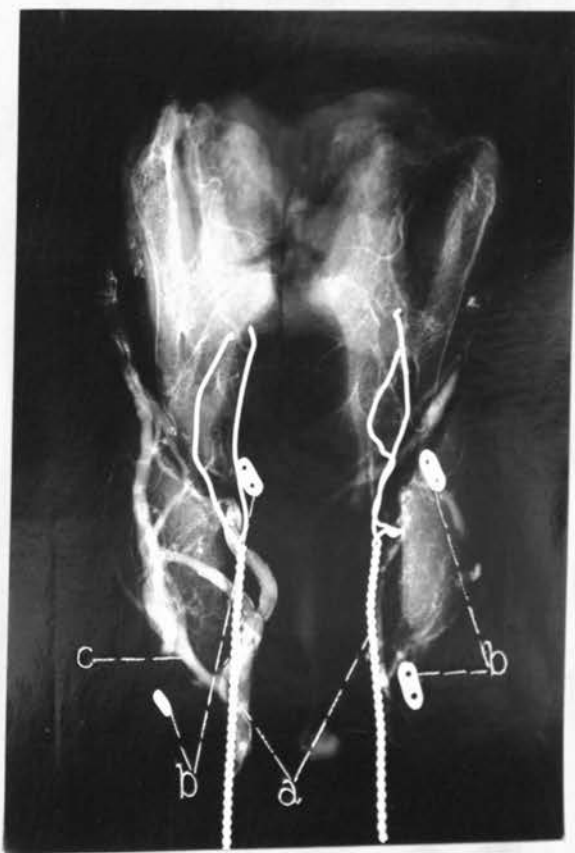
Roentgenogram showing relation of (a) the recurrent laryngeal nerves and (b) the parathyroid to the (c) blood supply of the thyroid. Antero-posterior view. Wire laid along course of nerve and, metal tags over parathyroids.
